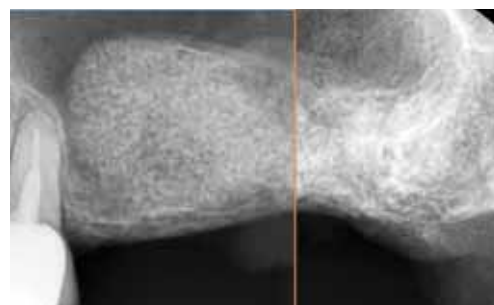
Periapical radiographs after sinus graft followed by repair of perforated membrane.
